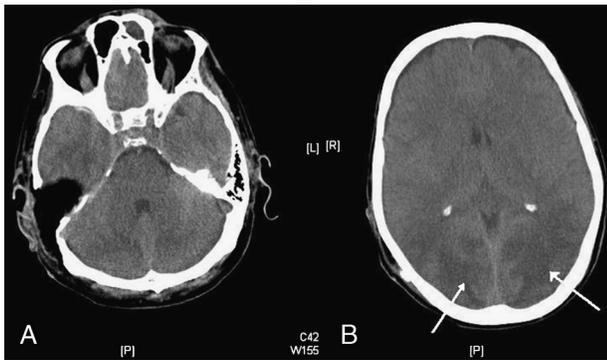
Axial CT scan shows postpetrosectomy changes with no evidence of hemorrhage (A). Arrows show areas of hypodensity in the parieto-occipital white matter with mild mass effect (B).
